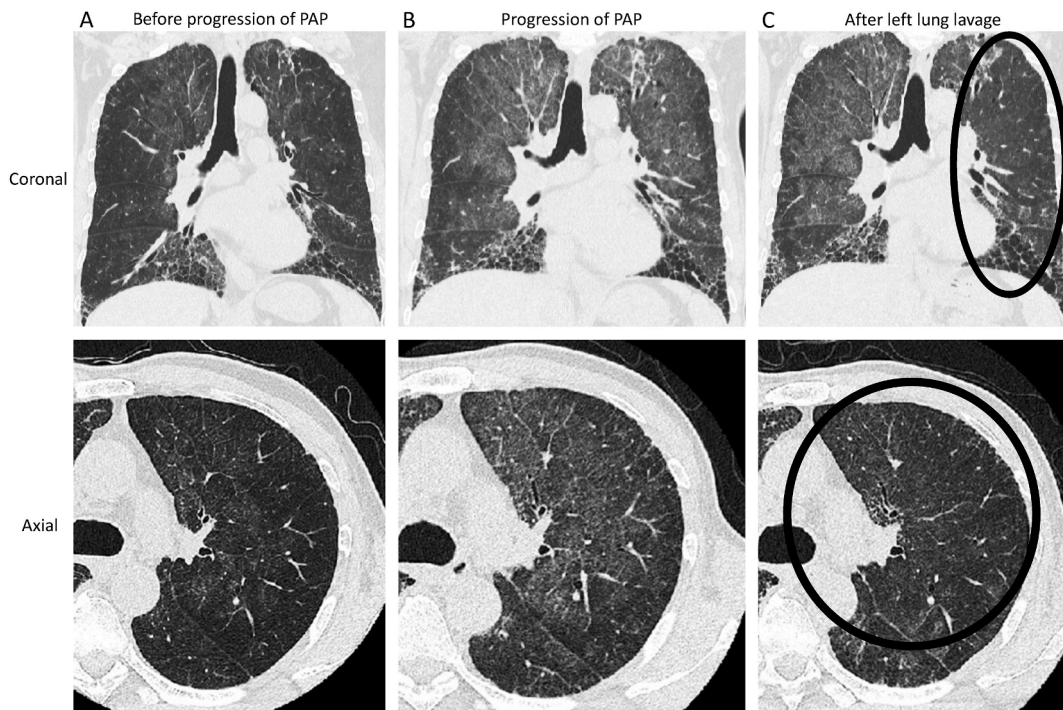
The computed tomography image showing progress of PAP (A) The image before progression of PAP. (B) PAP progressed in 2018, and (C) left lung lavage performed. The shadow of left lung improved (circle). PAP, pulmonary alveolar proteinosis.
